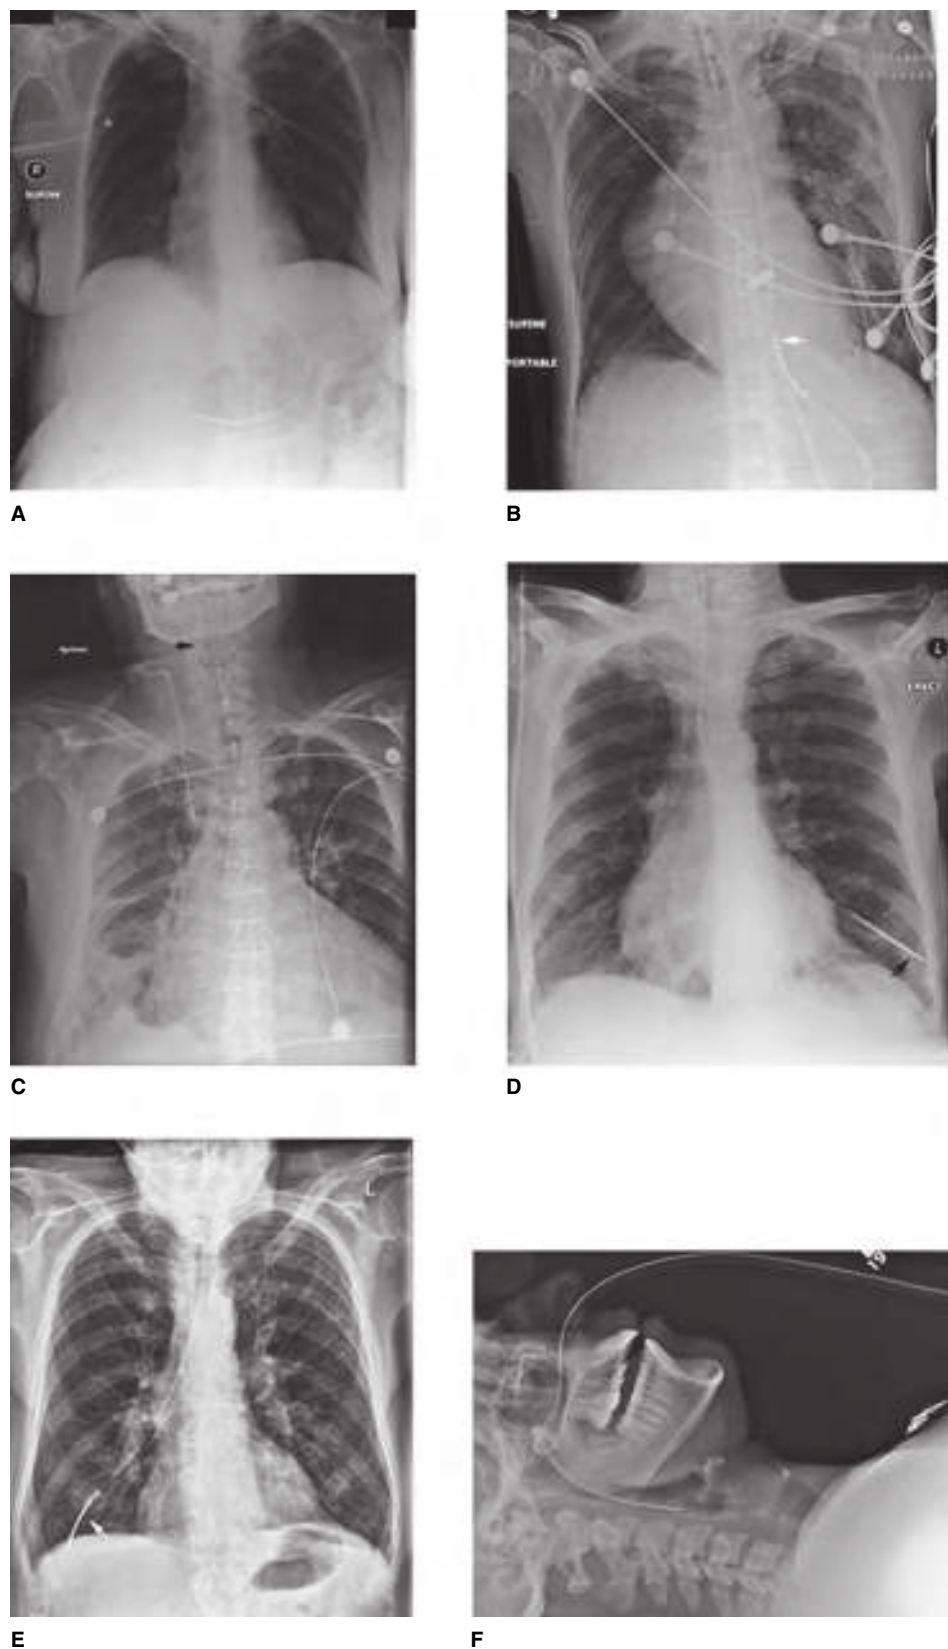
Radiographs of the inserted NG tube. A. The tip of the NG tube is in the stomach. B. The tip of the NG tube is in the esophagus after it curves in the stomach. C. The tip of the NG tube is coiled in the hypopharynx. D. The tip of the NG tube is in the left lower lobe of the lung. E. The tip of the NG tube is in the right lower lobe of the lung. F. The NG tube is knotted in the nasopharynx. (Photos used with permission from www.wikiradiography.net.)
